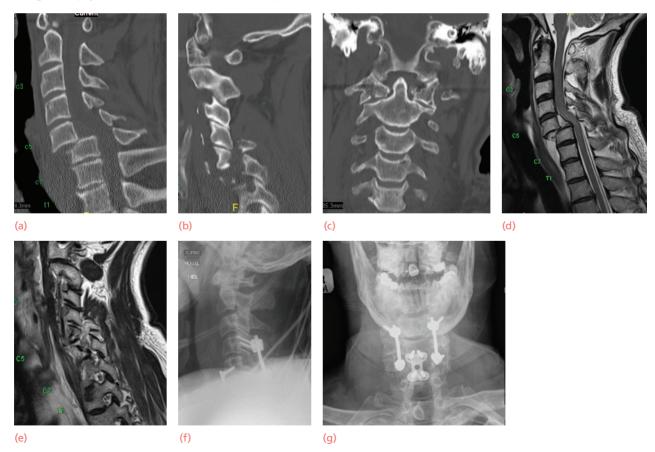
Cervical fracture-dislocation (a,b) CT scan in a cyclist with C5/C6 vertebral body listhesis and facet fracture-dislocation. (c) C1 ring fracture in the same patient shows the value of CT in detecting non-contiguous injuries which may be missed on X-rays. (d,e) MRI shows compression and cord injury and is useful to assess the facets on the parasagittal views. (f,g) Due to the facet fractures, anterior-only stabilization was not adequate and posterior fixation was added.
